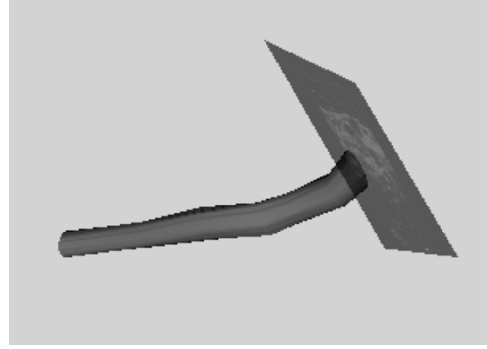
Screen shot of the data display for ultrasound screening system, showing a “neutral” 3-D vessel model and the ultrasound image plane.
